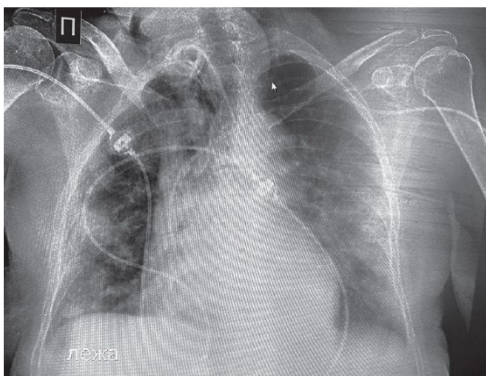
Chest X-ray (lying down)
